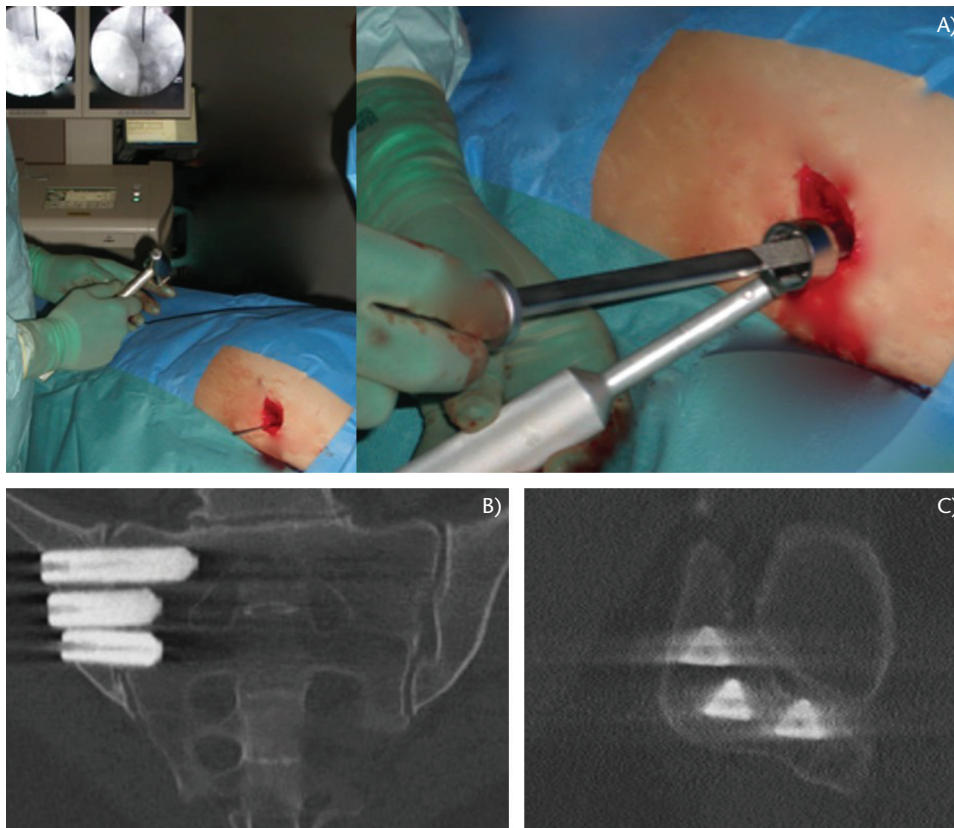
Minimally invasive surgery of the sacro-iliac joint (SIJ). (A) Patient is in the ventral position. C-arm-guided approach allows for precisely inserting the first guide pin and to measure the screw length. The guide is perpendicular to the plane of instability through the ilium and the sacrum. A larger guide pin allows the insertion of the screws. SIJ fusion can be obtained using three triangular screws. The good position of each screw has to be post-operatively confirmed by computed tomography scan (B and C).
